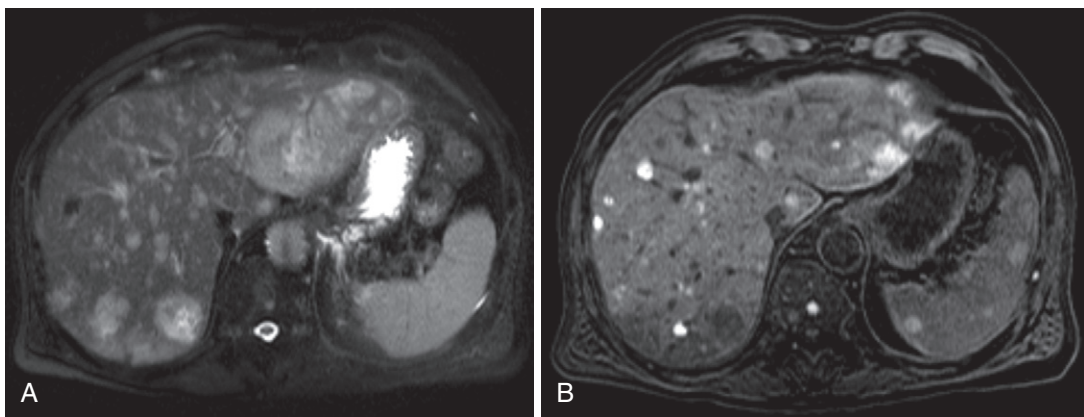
T1-weighted fat-suppressed image. The T2-weighted fat-suppressed image (A) reveals multiple nonspecific hyperintense lesions, many of which appear hyperintense on the T1-weighted fat-suppressed image (B) due to their melanotic content in a patient with metastatic uveal melanoma.
